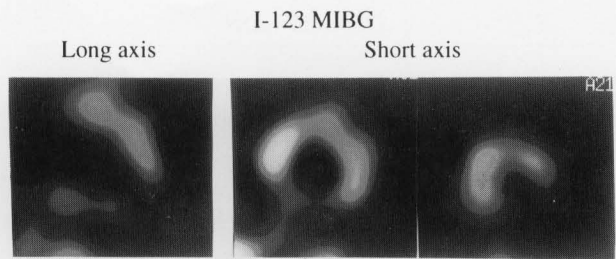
The defects in inferior and apex, and the reduced uptake in the anterior and lateral segments on resting I-123 MIBG myocardial scintigraphy were noted. The denervated but viable myocardium was demonstrated in the heart with sarcoidosis.
